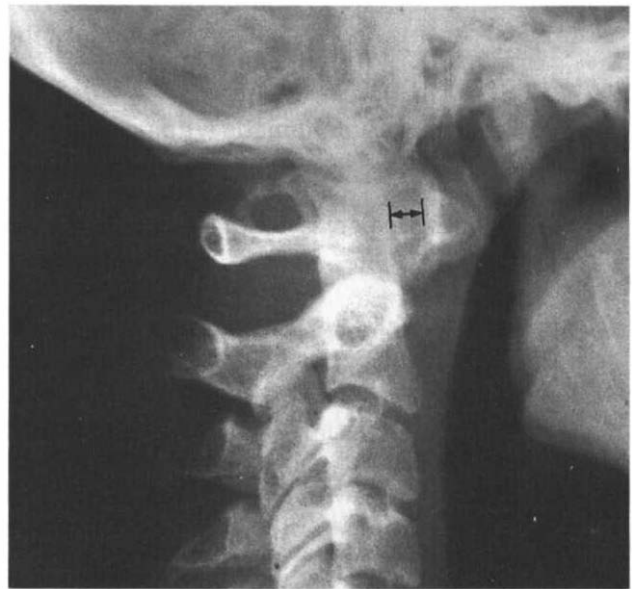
A clinical example of a bilateral anterior translatory displacement of C1 on C2. This is a radiograph of a healthy 21-year-old female who fell 4–5 ft onto her head from a climbing bar. She heard a loud snap and immediately had pain in her neck. There were no neurologic signs or symptoms. The displacement between the anterior dens and the posterior portion of the anterior ring of C1 measured 7 mm. This bilateral anterior translatory displacement should be considered clinically unstable. The radiograph shows another interesting finding. The little arch on the posterior ring of C1 has no known clinical significance but is frequently observed. It has at least two names, posterior ponticle and *foramen arcuale*. It is never seen in children but is partially or completely present in 12–16% of all adults.¹⁶³ The vertebral artery passes under it before entering the cranium. (X-ray courtesy of John Wolf, M.D.)
